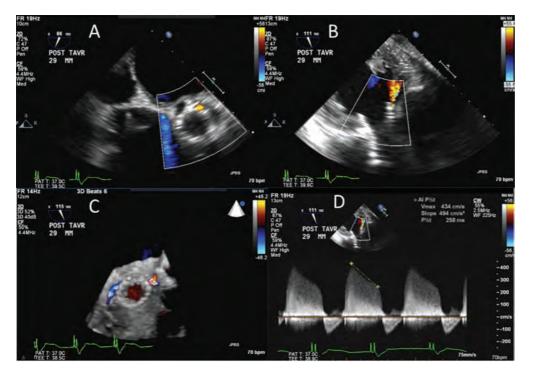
Paravalvular leak (PVL) assessment by 2D, 3D and Doppler measurements. While the PVL is assessed as mild by 2D and 3D measurements (panels A, B and C), Doppler measurement shows a pressure half-time of 258. ms, consistent with a moderate-to-severe PVL.
